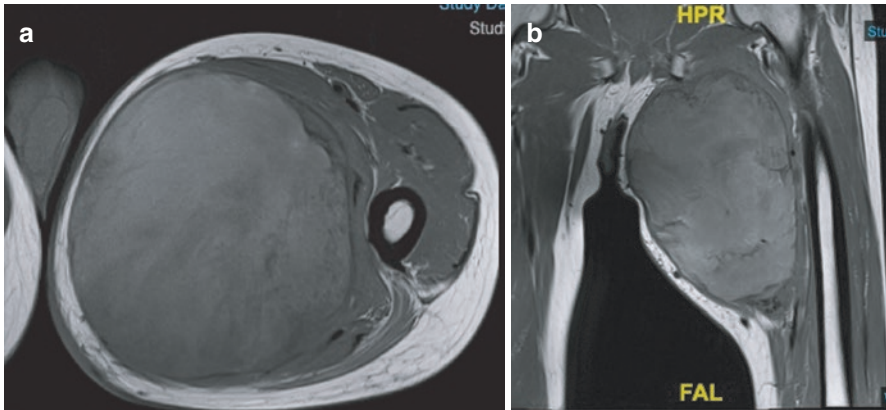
T1-weighted (a) axial and (b) coronal MRI images of massive adductor compartment undifferentiated pleomorphic sarcoma
